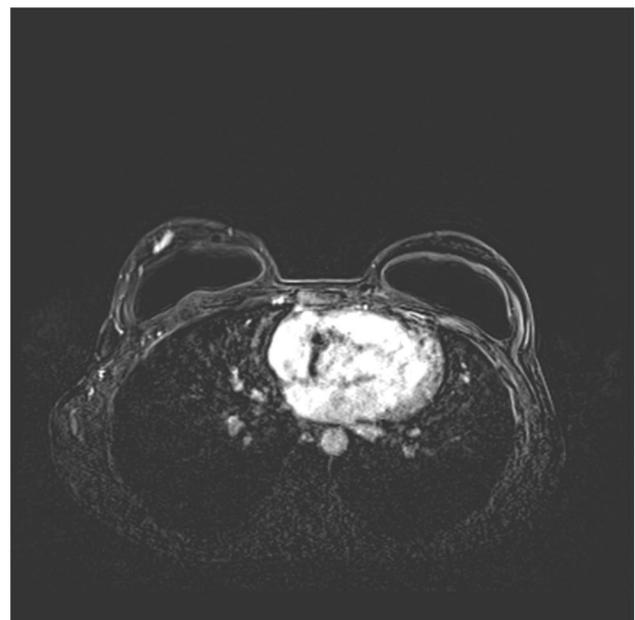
Fifty-six-year-old woman after bilateral mastectomy and reconstruction with implants. Post-contrast T1 subtracted image showing a small enhancing mass in the lower inner quadrant of the left reconstructed breast. Second look ultrasound with percutaneous needle core biopsy was benign, one year follow-up MRI was negative
